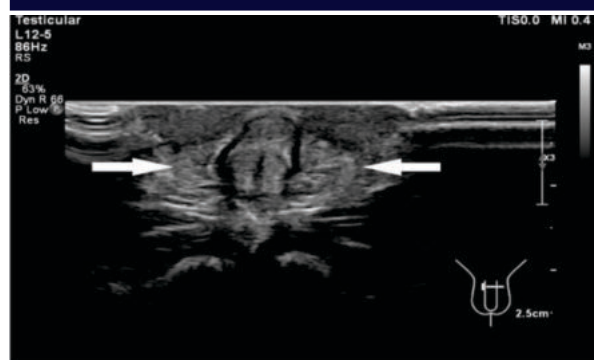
Ultrasound scrotum demonstrates absent testes (arrows).
